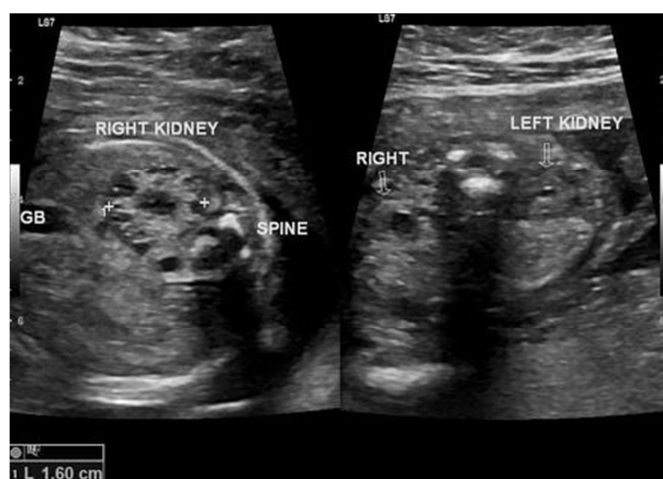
Ultrasonographic image of fetus, showing cystic dysplasia of kidneys.
